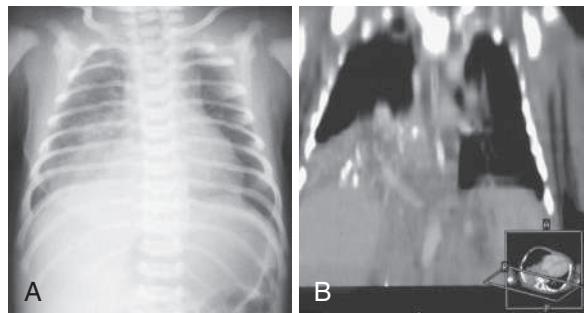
A, Plain chest x-ray showing changes in the region of the right lower/middle lobe of the lung. B, CT showing parenchymal changes in the right lower lobe of the lung in keeping with a sequestration. (From Corbett HJ, Humphrey GME. Pulmonary sequestration. *Paediatr Respir Rev*. 2004;5:59–68.)
